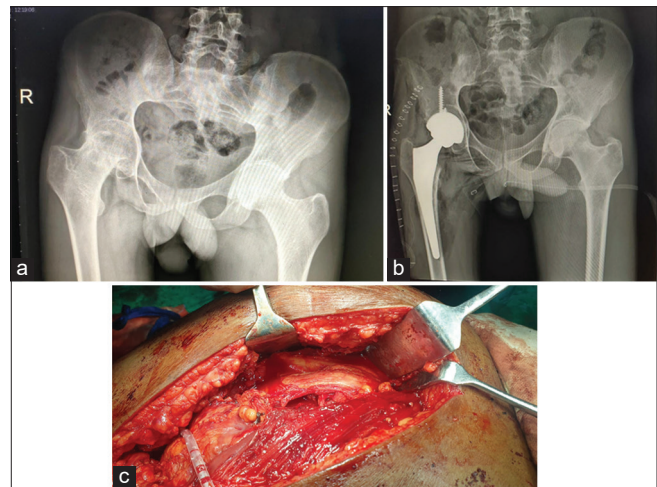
(a) Grade 4 right hip arthritis, (b) Postoperative radiograph of total hip replacement, (c) sciatic nerve variation
